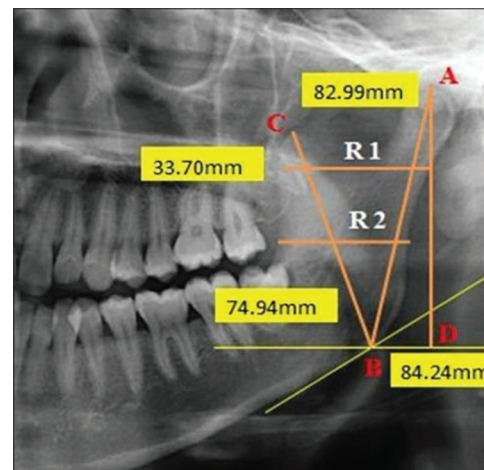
The five linear ramus measurements on digital panoramic radiograph. R1: Upper ramus breadth. R2: Lower ramus breadth. AB: Condylar ramus height. BC: Coronoid ramus height. AD: Projective ramus height
